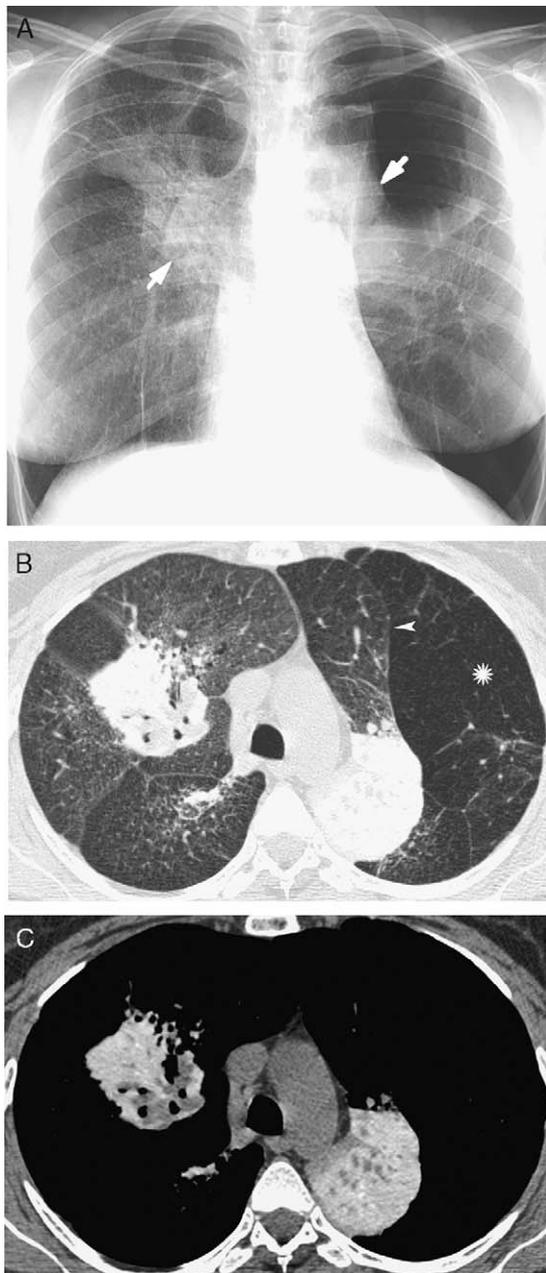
A 30-year-old woman with talcosis due to intravenous drug abuse. A, Posteroanterior chest radiograph shows large peri-hilar opacities (arrows), extensive upper lobe scarring and decreased attenuation and vascularity in the left lung. Tiny nodules are visualized in the right lung involving mainly the upper and middle lung zones. B, High-resolution CT scan shows conglomerate masses within the upper lobes and bilateral architectural distortion. Note displacement of the left major fissure (arrowhead) due to compensatory hyperinflation of the left lower lobe. Also note markedly decreased attenuation and vascularity of the left lower lobe (asterix) consistent with panacinar emphysema. Multiple small nodules and ground-glass opacities are seen bilaterally. C, CT image at the same level as B photographed at soft tissue settings demonstrates high attenuation of the bilateral masses consistent with talc deposition.
